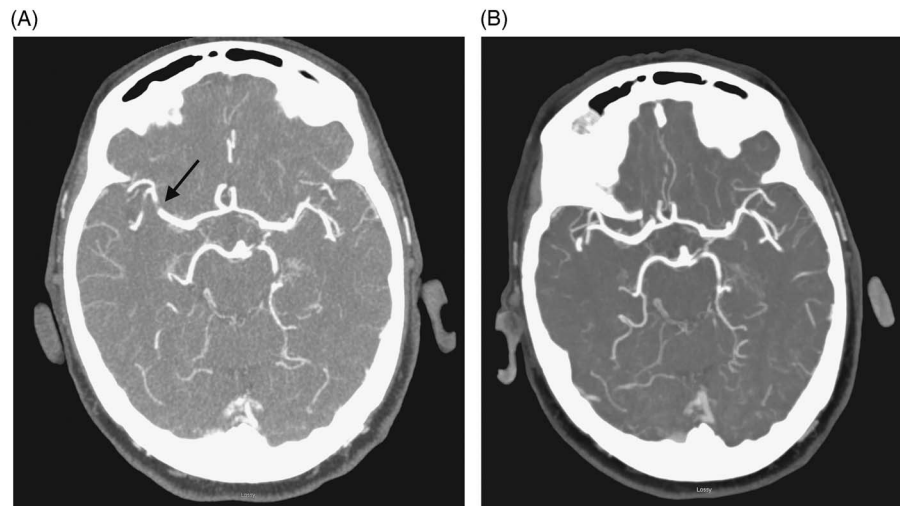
(A) CT angiogram demonstrating hyperdense MCA with acute clot visualized at M1. (B) Repeat CTA 24 hours following initiation of heparin demonstrates resolution of M1 clot.
